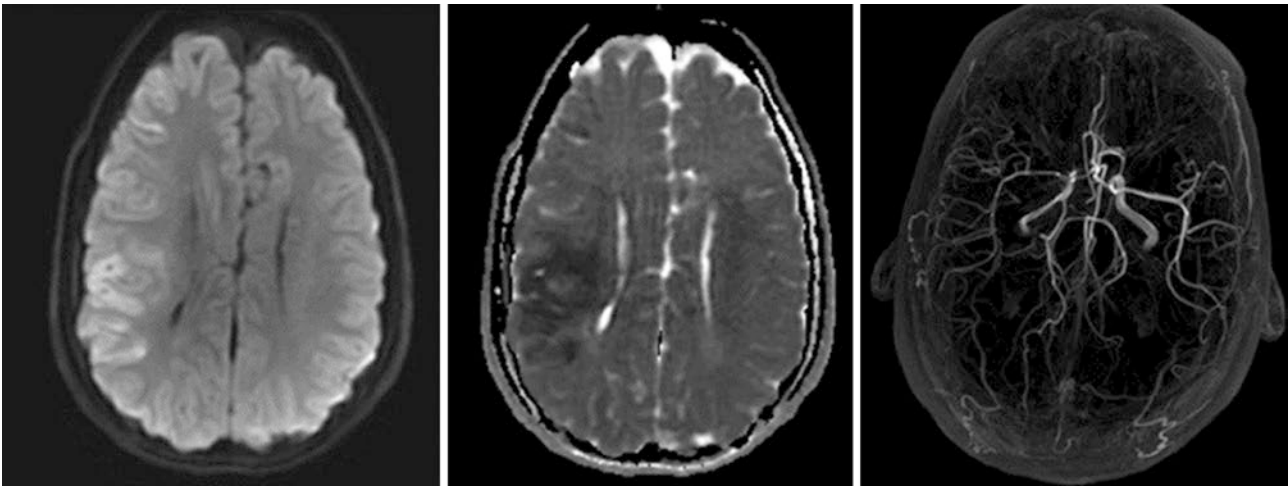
MRI of a 13 yo female with a right middle cerebral artery territory infarction. Diffusion-weighted imaging (*left*) and apparent diffusion coefficient (*middle*) show cortical and subcortical restricted diffusion in the right frontal and parietal lobes. Maximal intensity projection of 3D time-of-flight MR angiography (*right*) reveals diffuse narrowing of the right internal carotid artery and MCA, consistent with vasculitis
